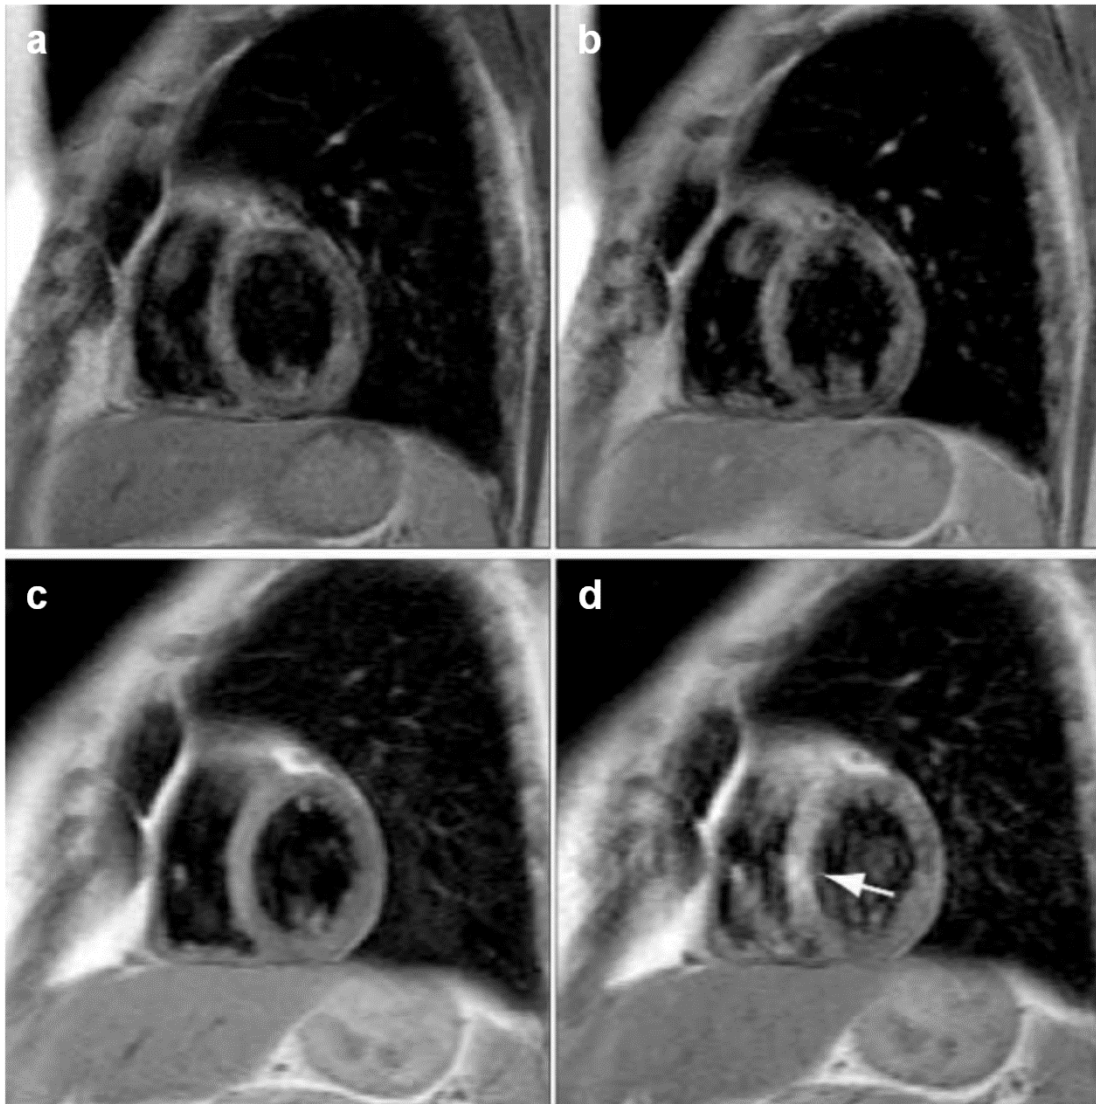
T1-weighted before (a and c) and after (b and d) contrast administration. Increased myocardial enhancement at 3 days following anthracycline chemotherapy (c and d) compared to Baseline images (a and b), with a prominent contrast enhancement within the septum (arrow). [Adapted from Wassmuth et al. (2001)].
